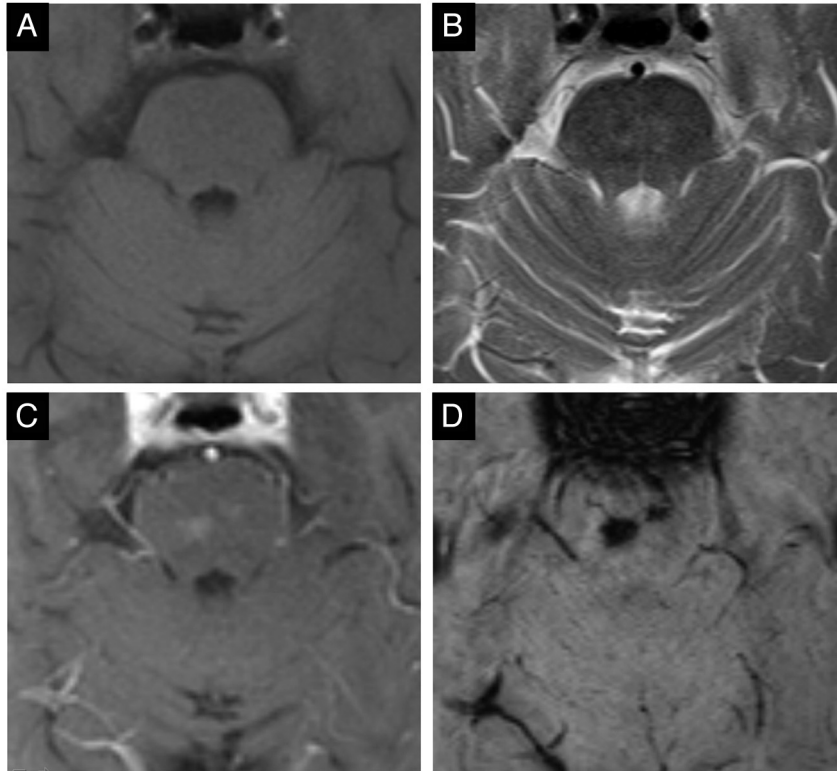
Typical case of 2 pontine BCTs (case 4). Isointense on T1- (A), slightly hyperintense on T2-weighted images (B), faint homogeneous enhancement after gadolinium (C), and considerable signal intensity drop on SWI (D).
